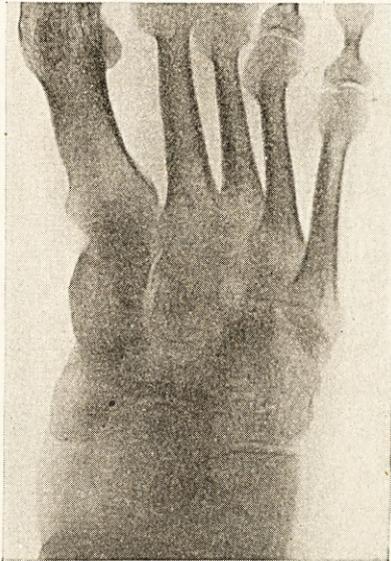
Case IV. (Robt. B.). X-ray of foot seven months after crushing accident. Diffuse osteoporosis of tarsus and metatarsus.
